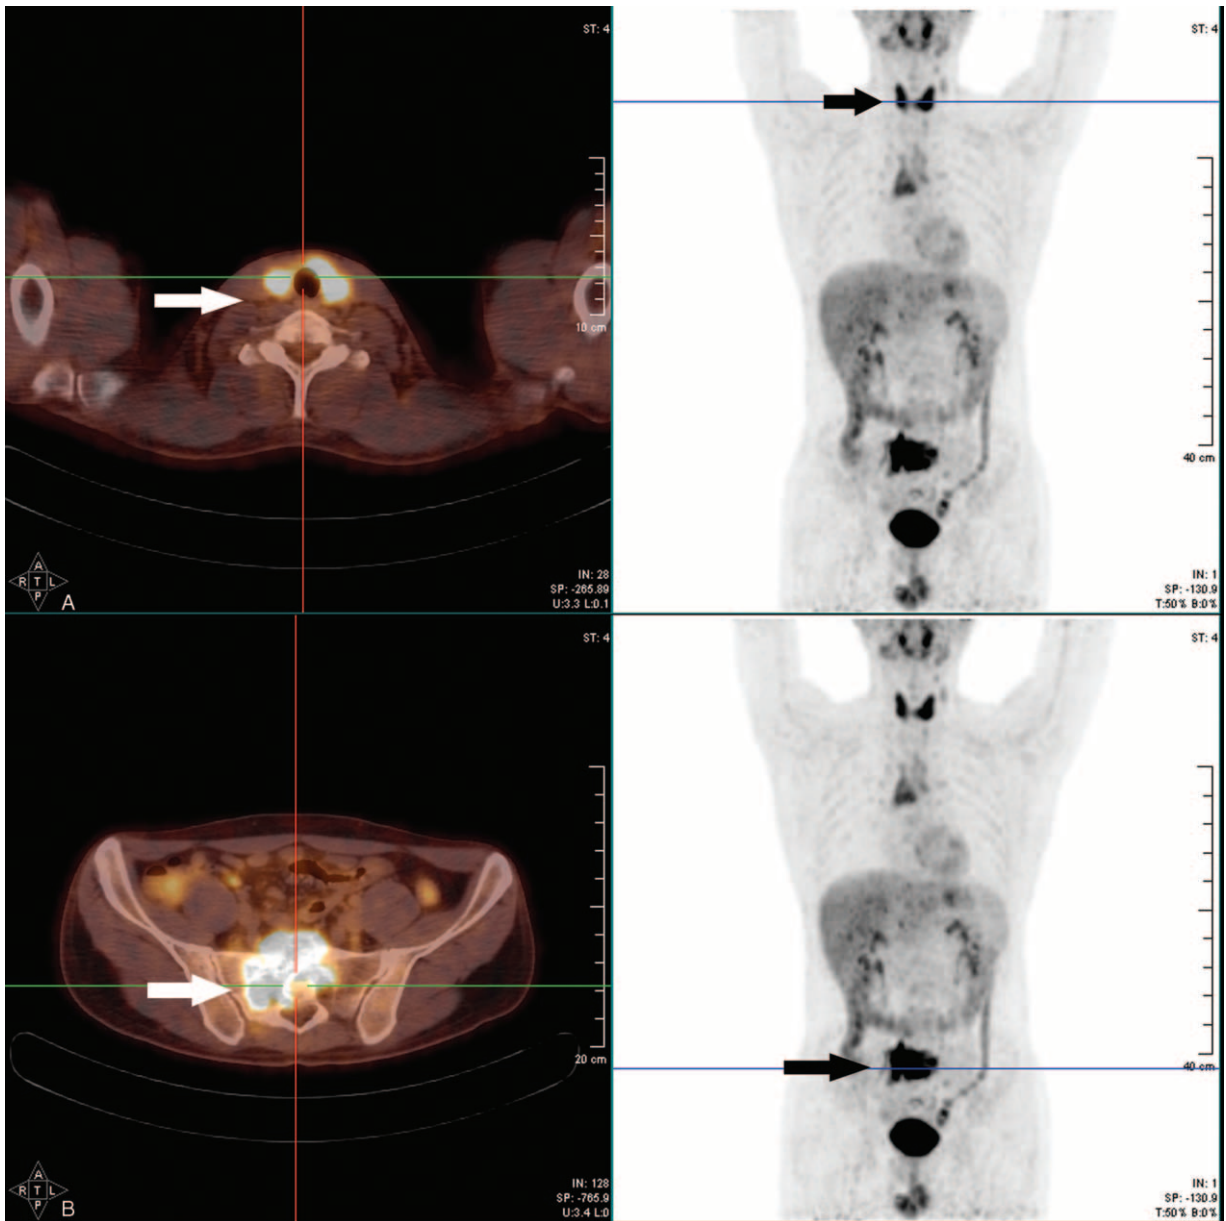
PET/CT (2012.03) showed FDG intense accumulation in the (A, arrow) thyroid (SUV value = 7.2) and (B, arrow) the vertebral body of S1-2 (SUV value = 10.7). FDG = fluorodeoxyglucose, PET/CT = positron emission tomography/computed tomography.
